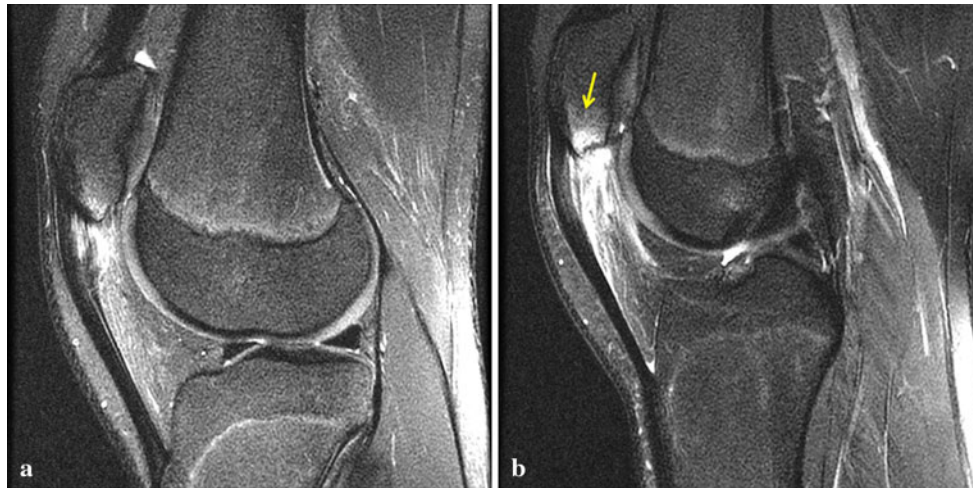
a Case 3 underwent an MRI identifying evidence of patellar tendinitis with a partial tear at the central 20 % of the tendon. Patella alta and fat pad oedema are also evident. b Following treatment with PRP, reactive oedema and osteolysis developed at the distal pole of the patella
